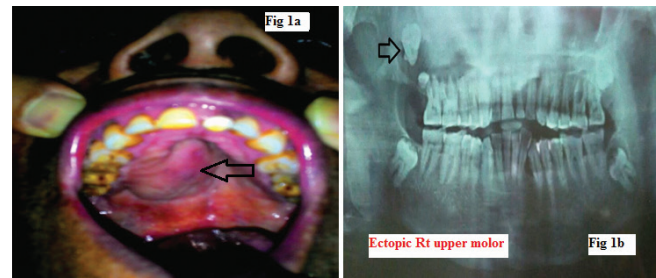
a) Intraoral examination showing a swelling over the right side of hard palate and missing right upper third molar tooth (large arrow); b) Orthopantomogram showing an ectopically erupted tooth within the right maxillary sinus (large arrow).
